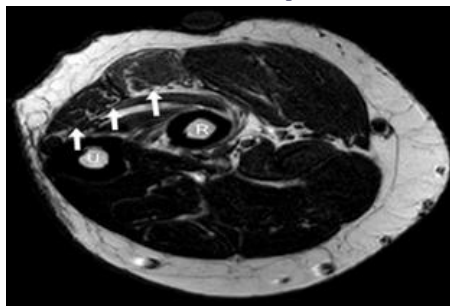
Axial T2 weighted magnetic resonance image at the level of right proximal forearm showing T2 hyperintense denervation atrophy of the extensor carpi ulnaris, extensor digiti minimi and extensor digitorum muscles (white arrows medial to lateral). U=Ulna, R=Radius
